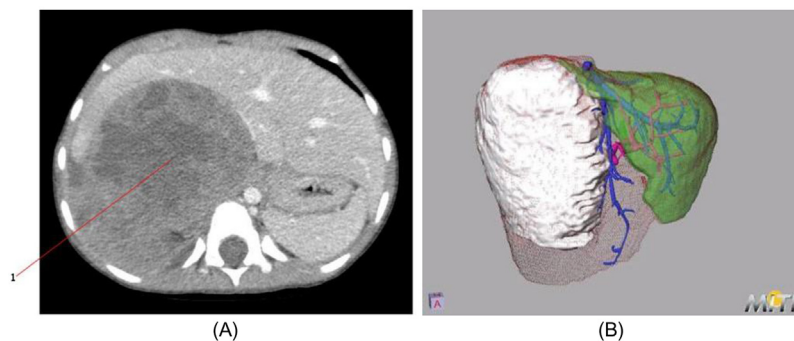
(A) Cross-section of hepatic cyst (1) in computed tomography. (B) 3D reconstruction of the cyst, which gives a much more detailed overview of the vessel structure and provides the possibility of exact volume calculations and remaining functional rest liver volume. *All from MITI.*
